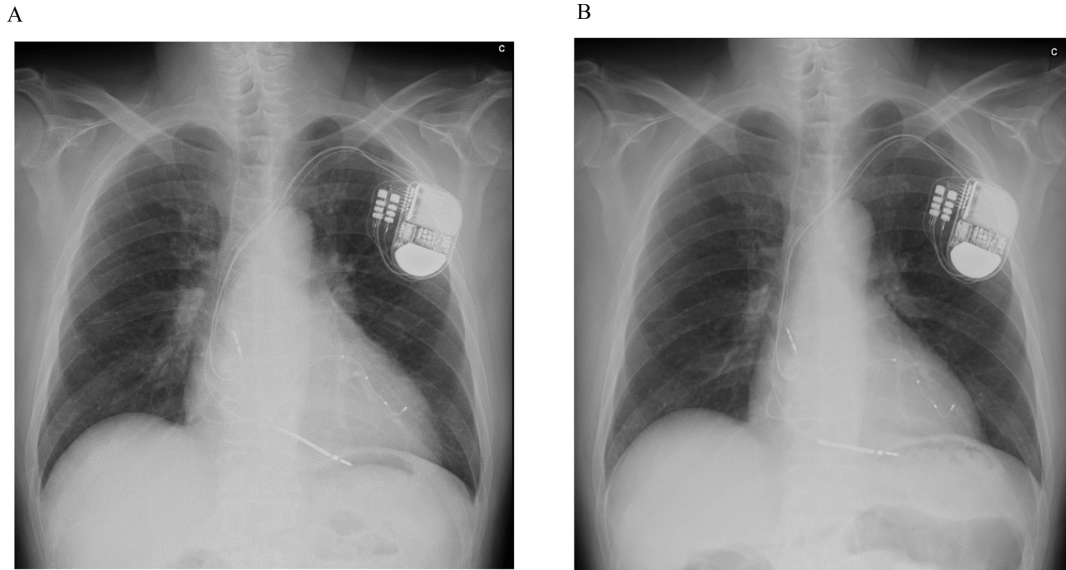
Chest X-ray on admission (A), and after administration of tadalafil (B).
